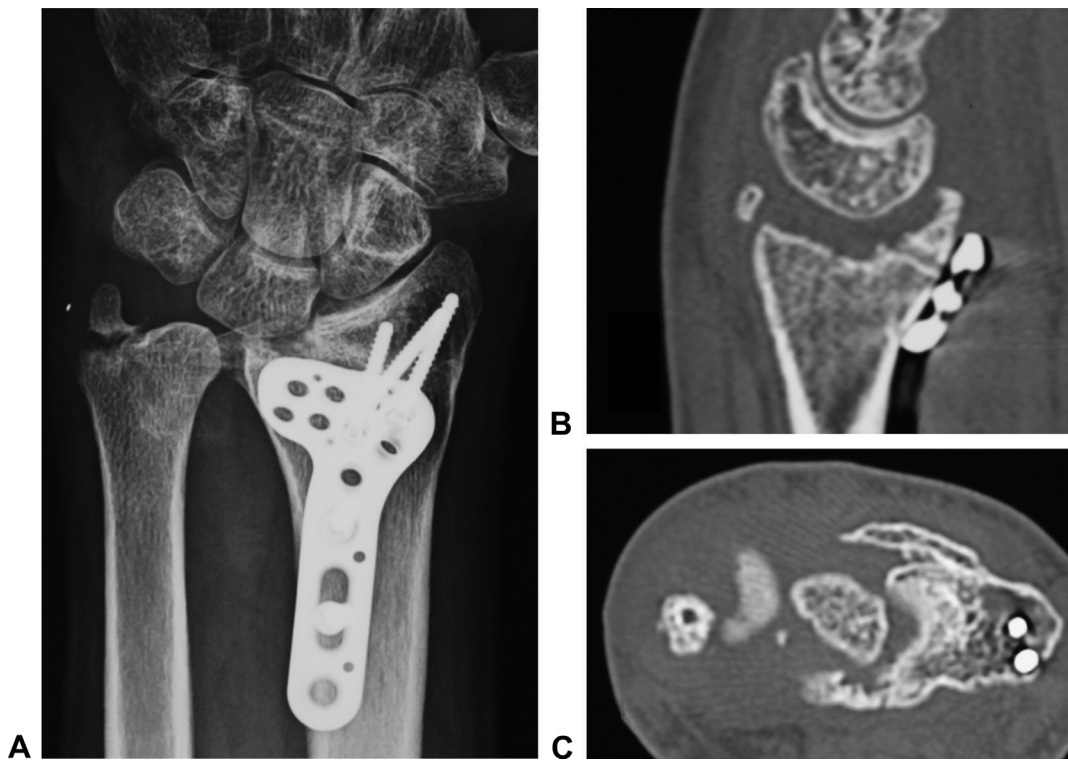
The ideal candidate for the index operation (patient 6): a massive osteochondral defect of 1 of the facets of the radius. The scaphoid fossa was not damaged. The sigmoid notch and lunate facet had cartilage damage, but the lunate and ulnar head cartilage were well preserved. A Preoperative radiographs. B Sagittal and C axial tomographic scan.
